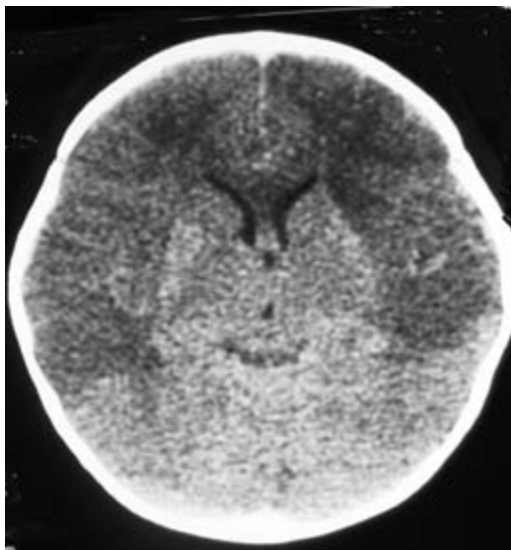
Infarction following sinus thrombosis in infancy. Axial CT image shows bilaterally symmetric areas of infarction adjacent to the interhemispheric fissure and bifrontally.
